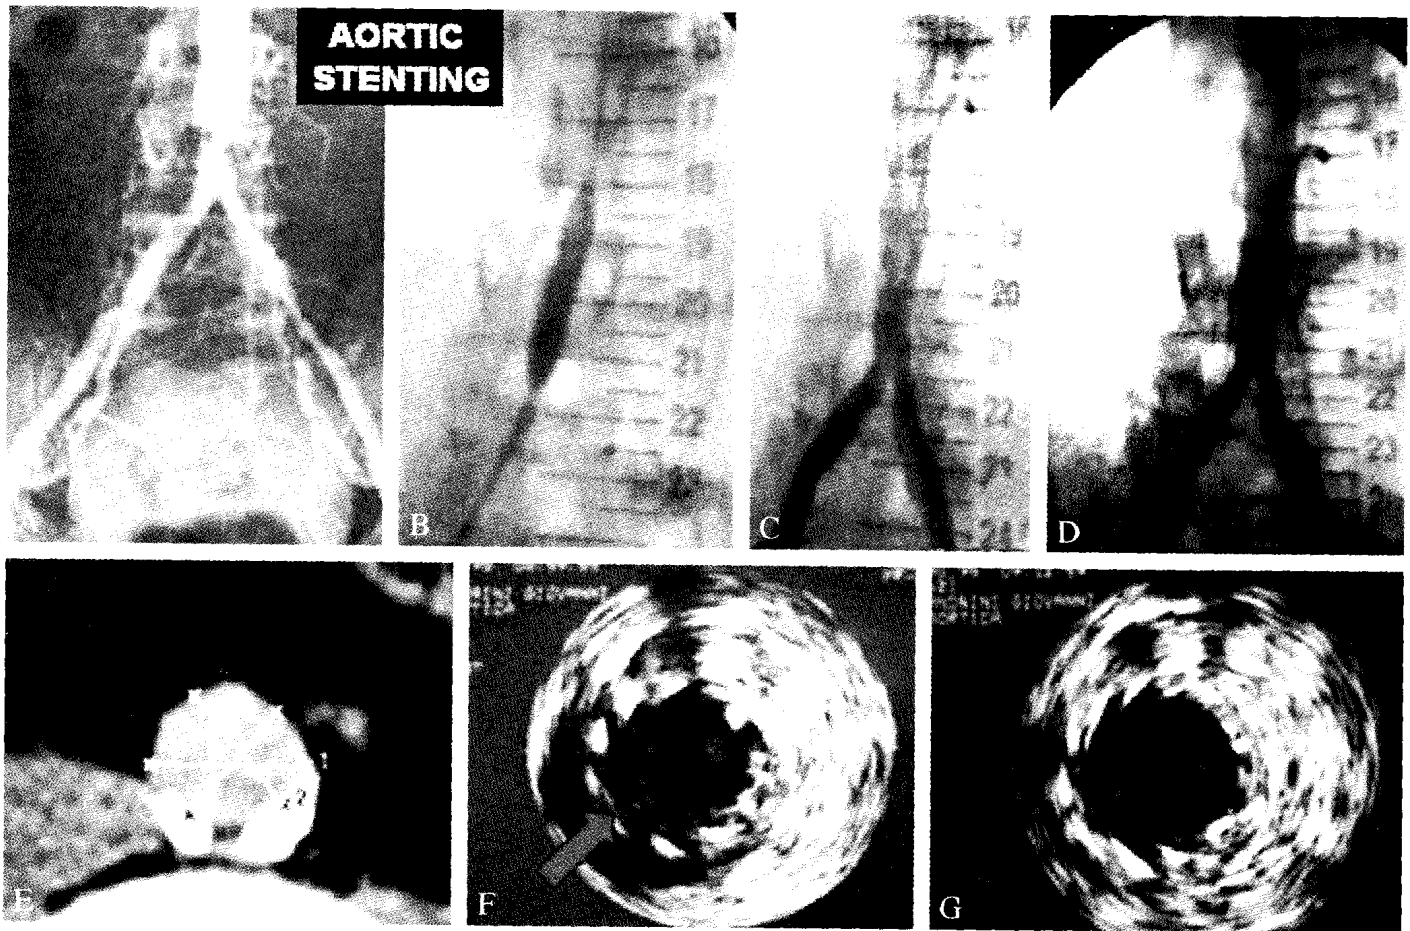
Severe stenosis of abdominal aorta: A) Preoperative aortography; B) Preoperative computed tomography scan shows heavy calcification of posterior aortic plaque and thrombotic material; C) PTA of the abdominal aorta with a 14 mm balloon catheter and an Extra-Jarge Palmaz stent; D) Intraoperative fluoroscopy with an apparently good result; E) Intravascular ultrasound (IVUS) shows incomplete adhesion of the stent to the aortic wall; F) Final result after a supplemental dilatation of the stent; G) Final IVUS control.
